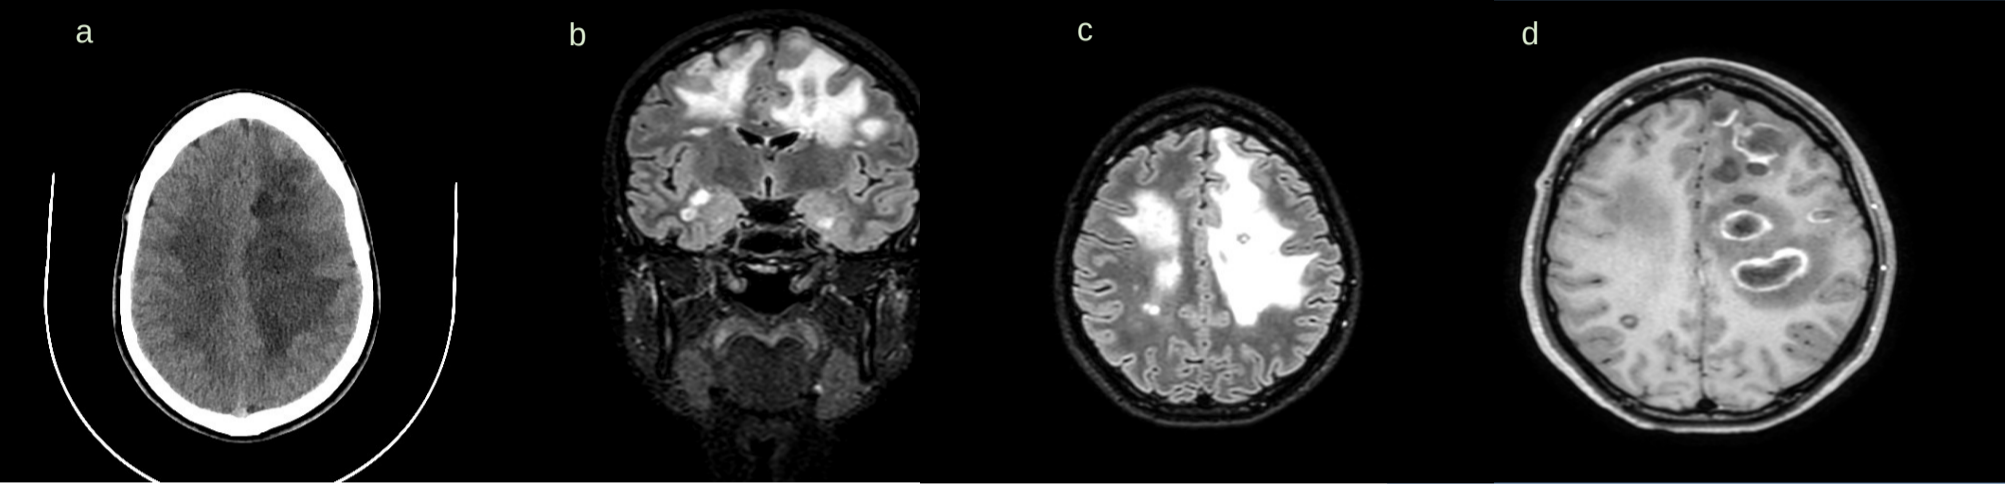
CT scan (a) and first MRI on admission: coronal flair (b), Axial FLAIR (c), T1, with gadolinium (d)
